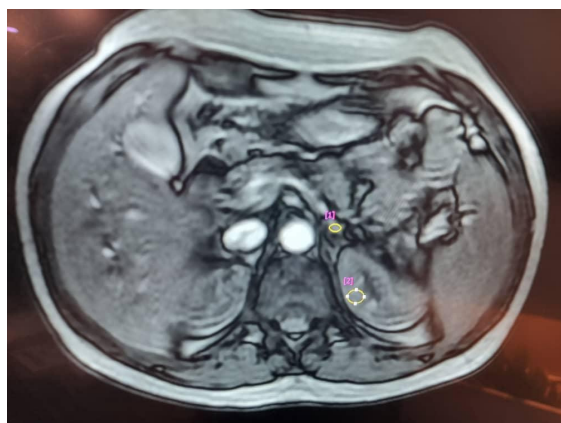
ROIs in abdominal cross-section MRI T2* for iron overload processing and calculation: [1] Adrenal gland and [2] Kidney
